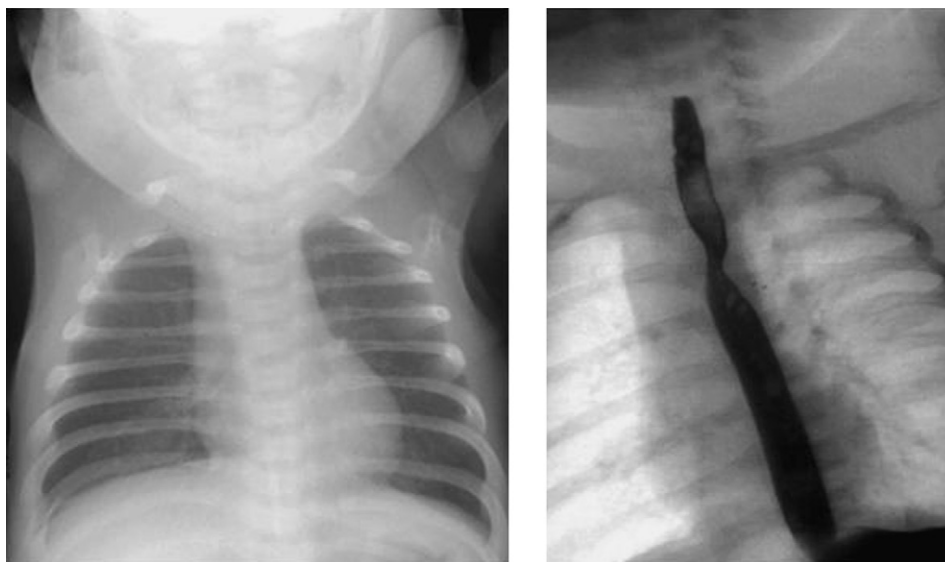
Anterior–posterior (AP) radiograph of the chest in a child with a double aortic arch. *Note:* Indistinct view of the trachea on the AP view. AP esophagram showing compression of the upper thoracic esophagus by the double aortic arch: the more inferior (caudad) indentation is due to the left aortic arch and the more superior (cephalad) indentation is due to the right aortic arch.
